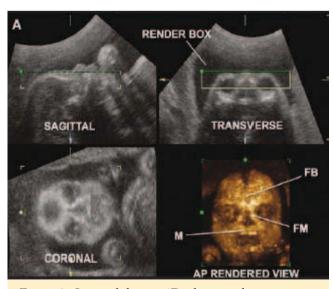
State-of-the-art 4D ultrasound representation of a fetus
